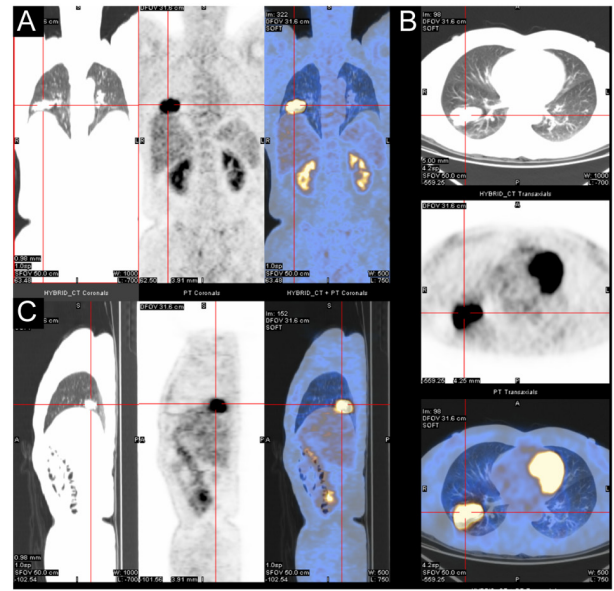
Multi-slice and multi-view display of fused computed tomography and positron emission tomography-computed tomography scan images. (A) Anteroposterior, (B) axial fused and (C) lateral images.
